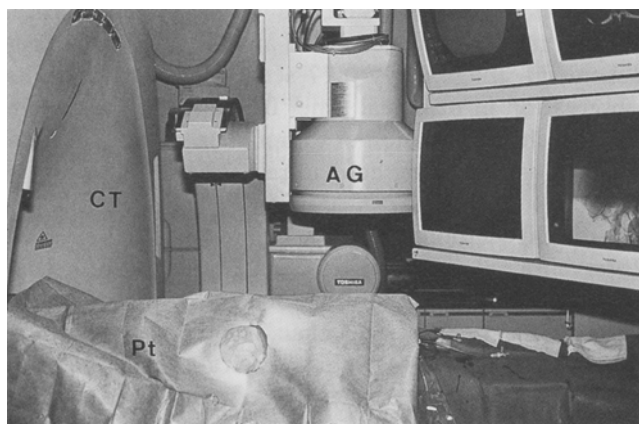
Interventional radiographic-CT/Angio system. This system combines a CT and an angiography system (AG) in a collinear arrangement. Pt, Patient.
